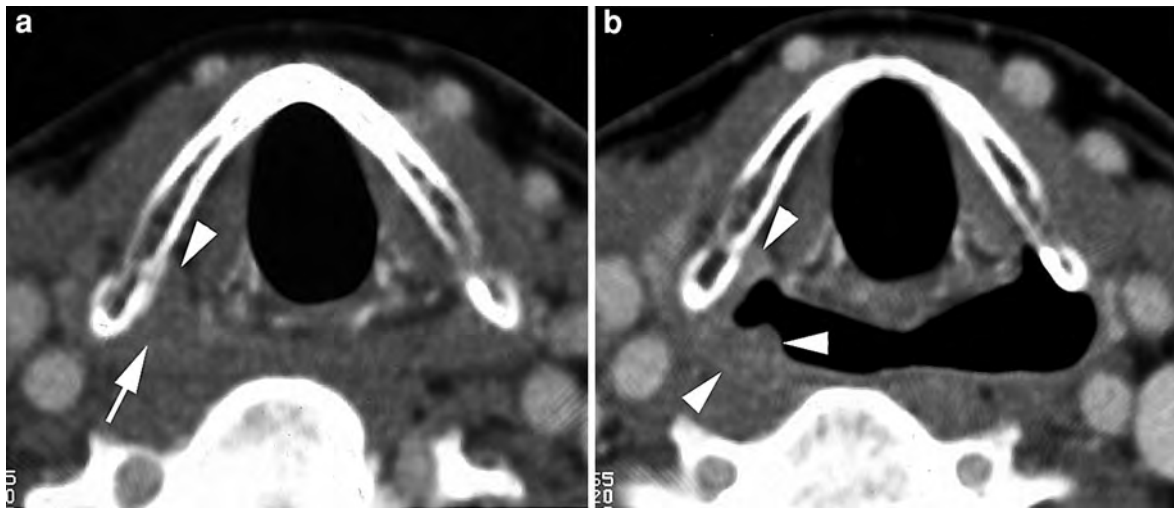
Contrast-enhanced single-slice spiral CT-images in a patient suffering cancer of the pyriform sinus. a Axial image during quiet breathing shows subtle soft tissue thickening in the apex of the right pyriform sinus (*arrow*); some evidence of subtle infiltration or displacement of the paraglottic space fat is
